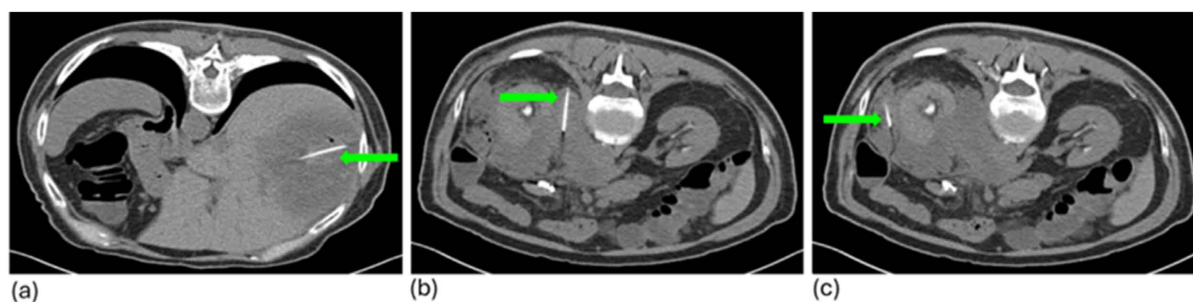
A repeat CT-guided percutaneous CIPI™ procedure shows intratumoral drug delivery into the (a) right liver mass, (b) left adrenal gland mass, and (c) left pararenal metastatic lesions, using a 22-gauge spinal needle (shown with a green arrow).
